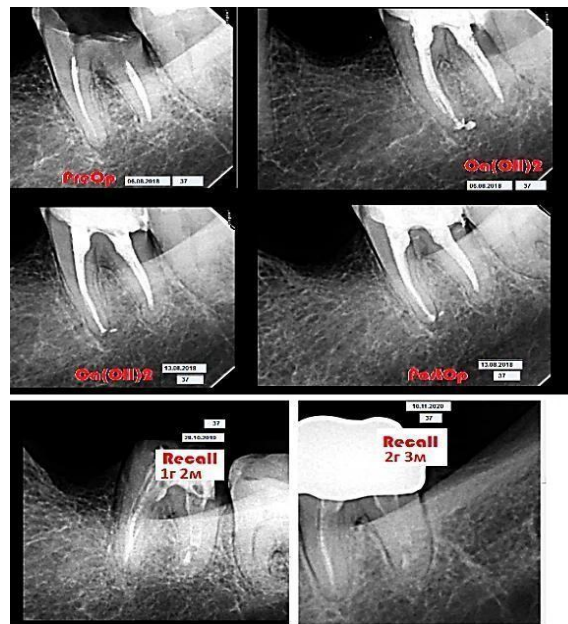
Radiographs of tooth 37: diagnostic; during treatment with a calcium-containing material for temporary root canal obturation; after permanent root canal filling; 14 months after completion of treatment; 2 years and 3 months after completion of treatment
